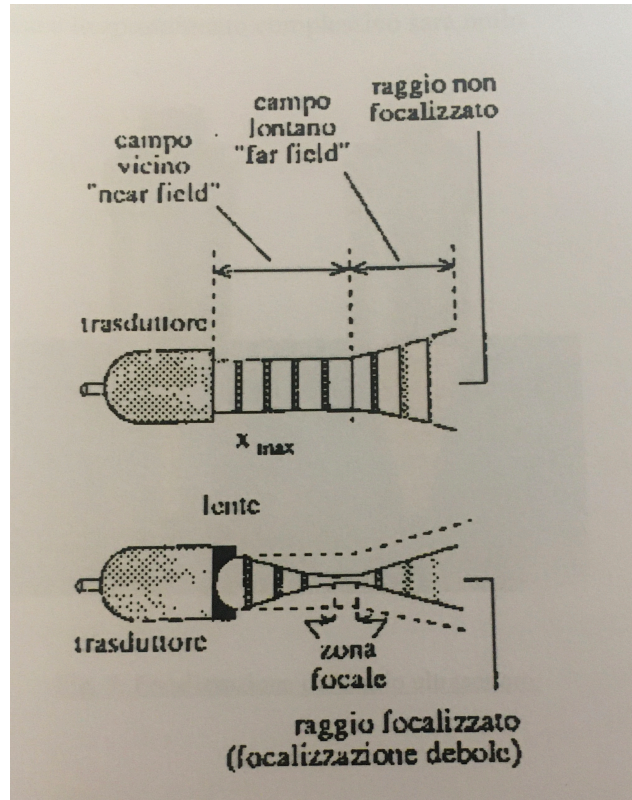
Concepts of near field and far field in ultrasound
